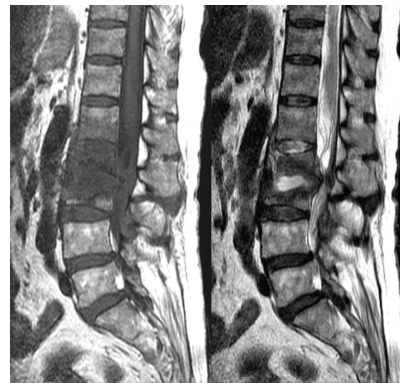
Sagittal T1- and T2-weighted magnetic resonance imaging revealed L2-L3 infectious spondylitis with epidural abscess accumulation.
